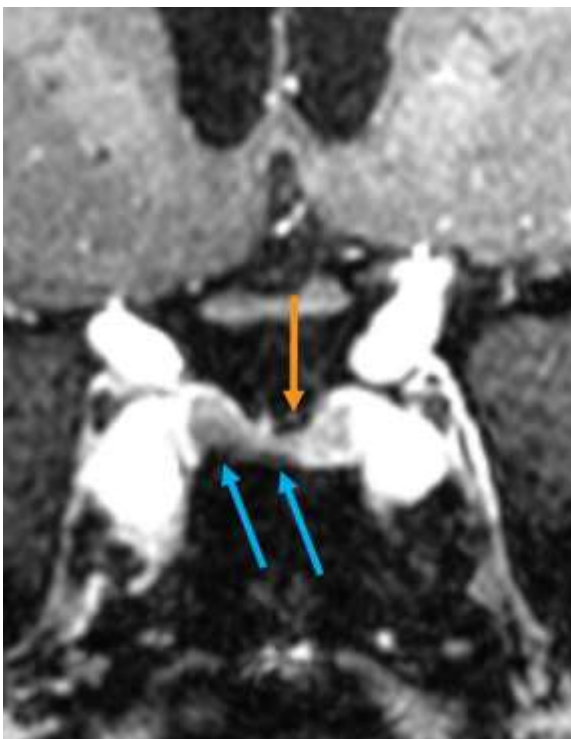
An 83-year-old female who was referred for a brain MRI for a posterior communicating artery aneurysm follow-up. Coronal C+3D-FS-T1 MPRAGE shows round-shaped susceptibility artifacts in the base of the adenohypophysis (blue arrows), which may mimic a hypointense adenoma and limit the assessment of the base. A cystic-appearing T1 hypointense area immediately lateral to the stalk and superior to the gland (orange arrow) is separated by a thin membrane and is continuous with adjacent CSF in other slices (not shown). This was favored to represent an entrapped CSF between the gland and the diaphragm, mimicking a cystic mass.
